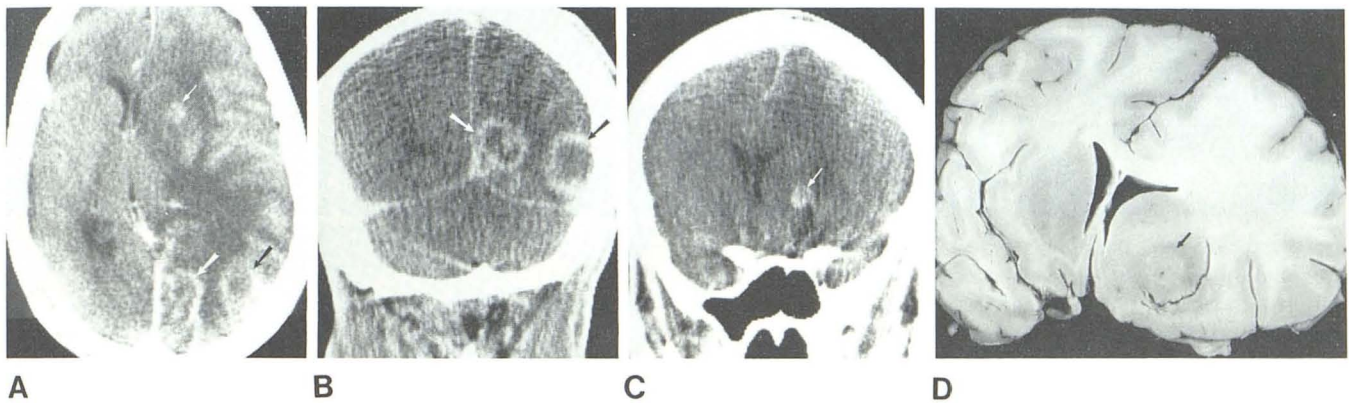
Second CT study with 79.3 g of iodine in axial (A) and coronal (B and C) views documented four lesions with hypodense centers and enhancing rims of variable thickness. Largest lesions were in left occipital lobe and at parietal-posterior temporal junction (long arrows); the smallest were in the left basal ganglia (small arrows, A and C) and left frontal lobe (not shown). Midline shift to right, left lateral ventricular compression, and extensive edema were also seen. Coronal sections of brain (e.g., D) showing left basal ganglionic mass (arrow) correlated well with corresponding coronal scan (C).
